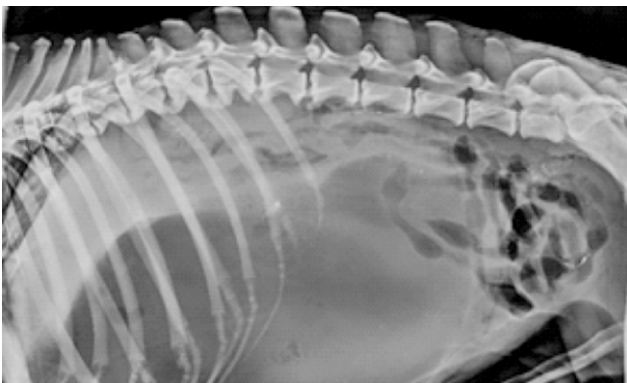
Lateral radiograph of Case 1, demonstrating spondylosis deformans, Grade 1 (white arrow)-bony spur not protruding beyond the caudal/cranial edge of the vertebral border of T9-T13, and L1-L3.
